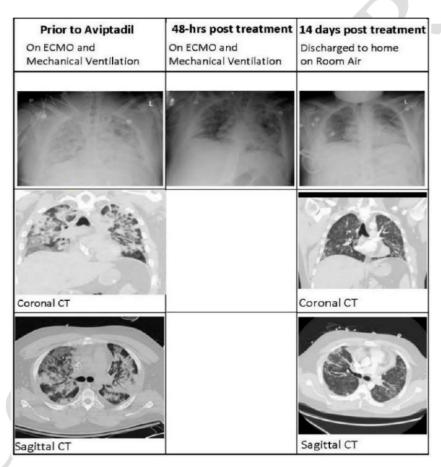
Chest x-ray and CT imaging of a patient initially treated while on mechanical ventilation and extracorporeal membrane oxygenation for Critical COVID-19 with respiratory failure
